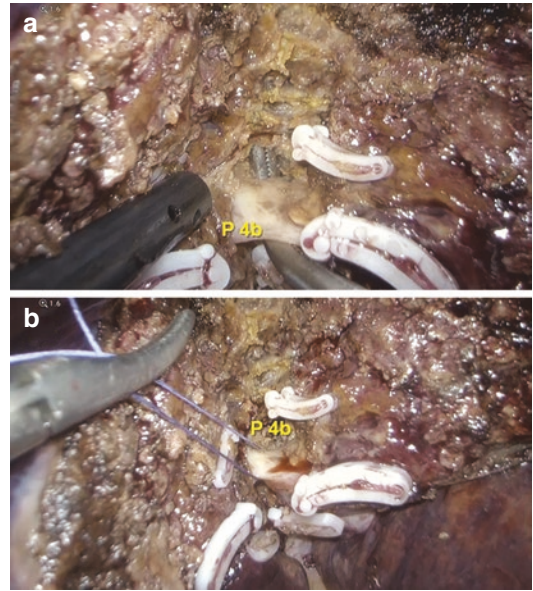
Portal pedicle to S4b (P4b) is isolated by ultrasonic dissector (a) and encircled with a tape (b)
